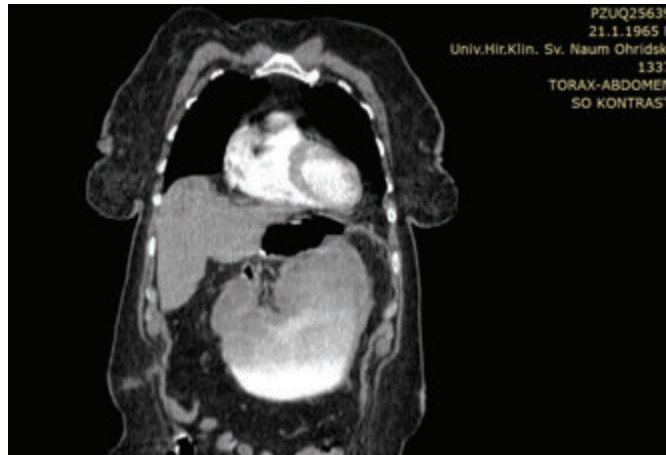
Postoperatively, a follow-up CT
